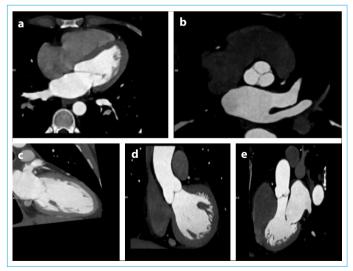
Apical four chamber axial image (a), axial image for aortic valve (b), sagittal images aortic valve, ascending aorta (c), sinus heights to the annulus (d), and vertical long axis LV 2-chamber mitral valve leaflets, posterior, papillary muscle and associated chordae tendinea (e).
